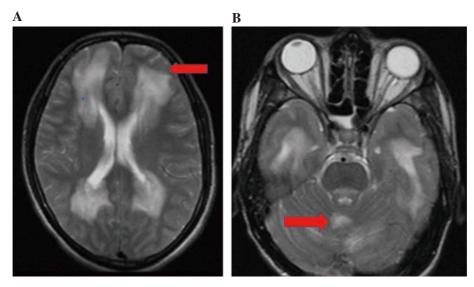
T2WI brain magnetic resonance imaging of a 20-year-old male. A: Hyperintensities in the subcortical areas (red arrow); B: Involvement of the tectum of the pons and cerebellum and deep white matter (red arrow).
